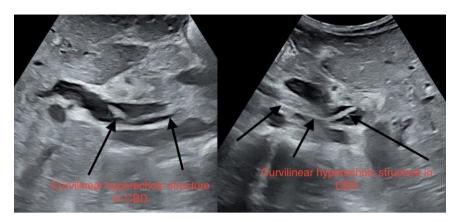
(A,B). Ultrasound reveals curvilinear non-shadowing strife within the dilated CBD (Strife sign)
